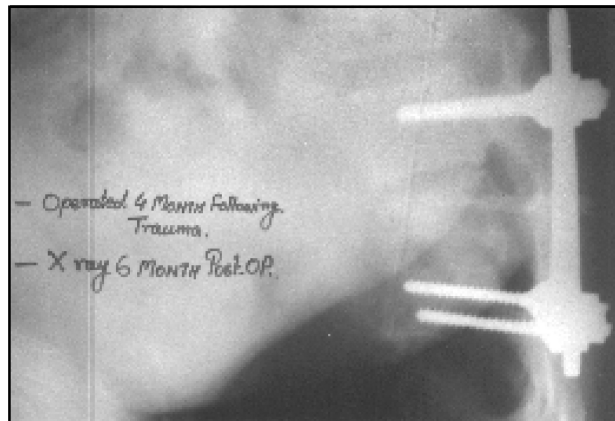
X-ray photograph of a patient managed with steffee plates.
